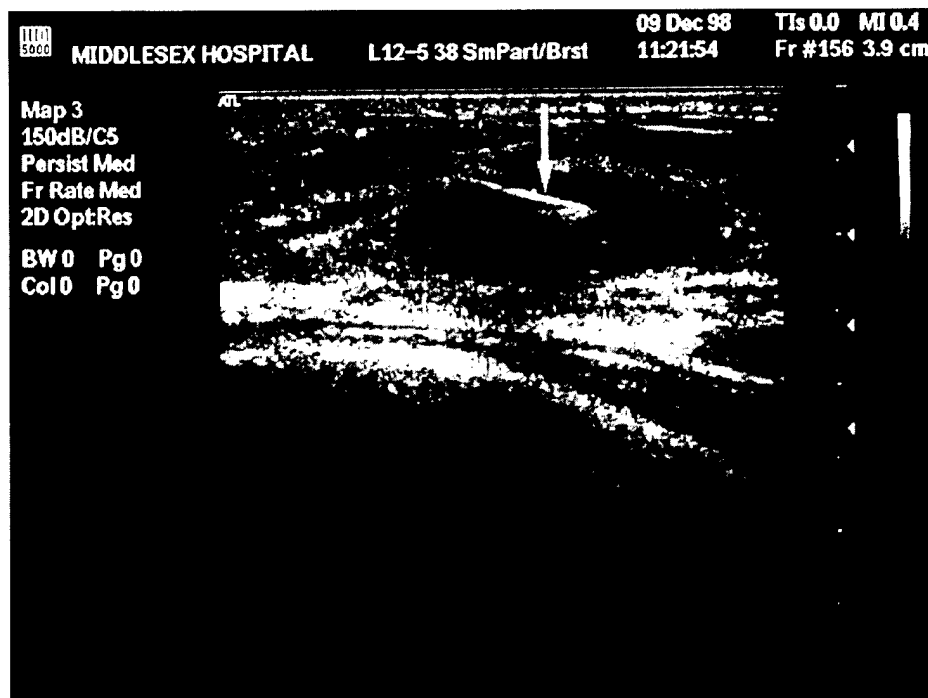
Ultrasound scan of a laser fibre (arrow) positioned in a fibroadenoma immediately prior to ILP.
